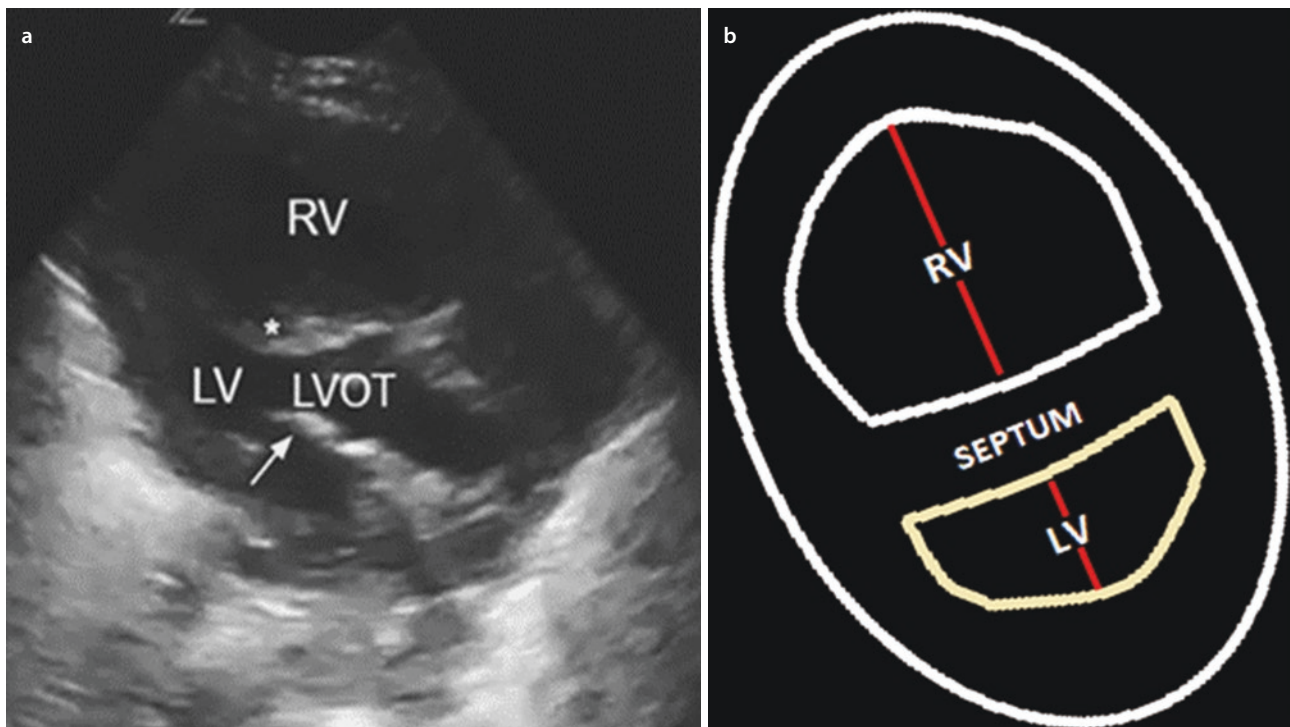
a Parasternal view shows a severely dilated RV, septal bowing (asterisk). (Image courtesy of Dr. Shira Shore). b Graphic displaying D-sign seen in parasternal short-axis view. RV dilation causes septal flattening and D-shaped LV. The D-sign can be due to RV pressure overload (e.g., pulmonary embolism, pulmonary hypertension) or volume overload (e.g., tricuspid regurgitation, aggressive fluid resuscitation). D-sign seen during diastole and systole is likely due to pressure overload, whereas D-sign seen only in diastole is likely due to volume overload
